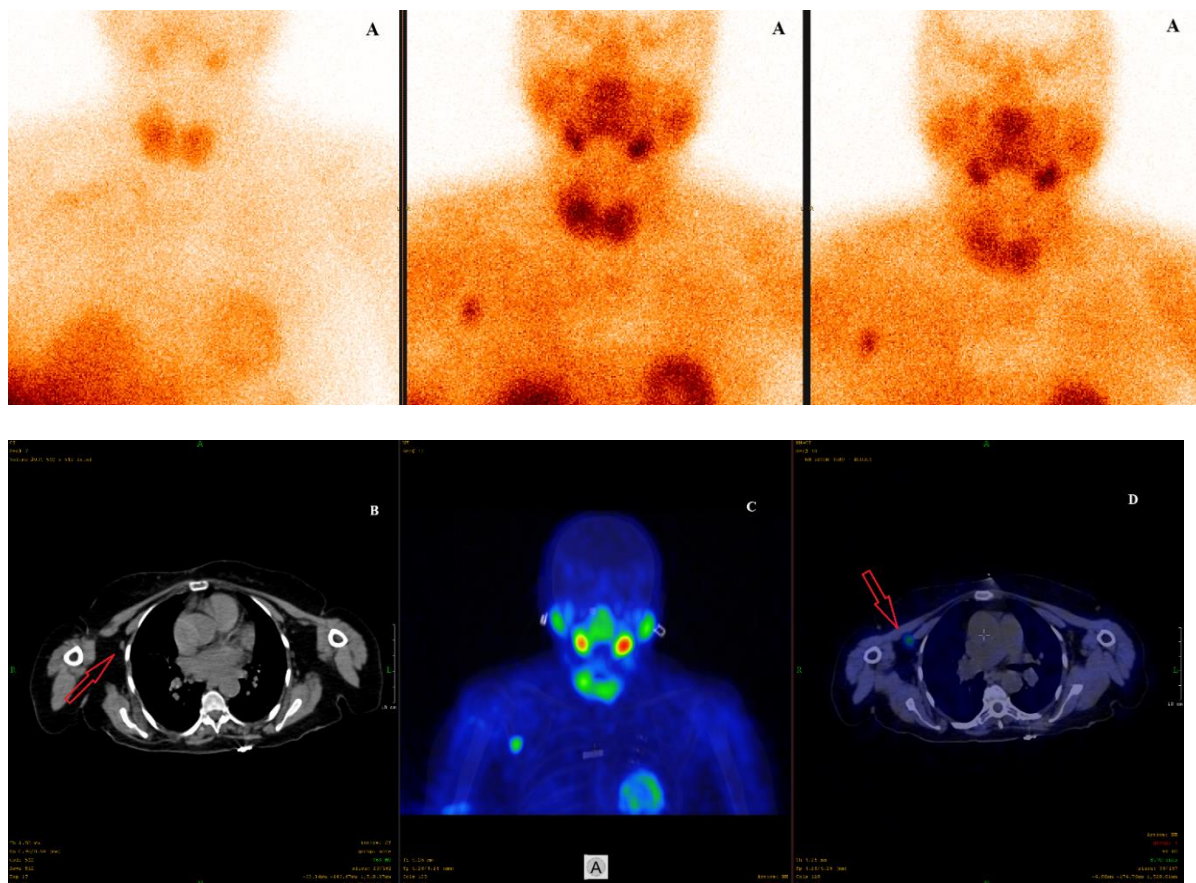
Combined planar and hybrid SPECT/CT parathyroid imaging in a 39-year-old woman with primary hyperparathyroidism. (A) Early planar ^{99m}Tc -MIBI scintigraphy demonstrates uptake limited to the thyroid gland, with no definite ectopic focus identified. (B) Axial CT image shows the ectopic lesion in the right lateral thoracic/right axillary region (red arrow). (C) Coronal fused SPECT/CT image demonstrates focal tracer uptake corresponding to the lesion. (D) Axial fused SPECT/CT image further confirms the ectopic parathyroid adenoma.
